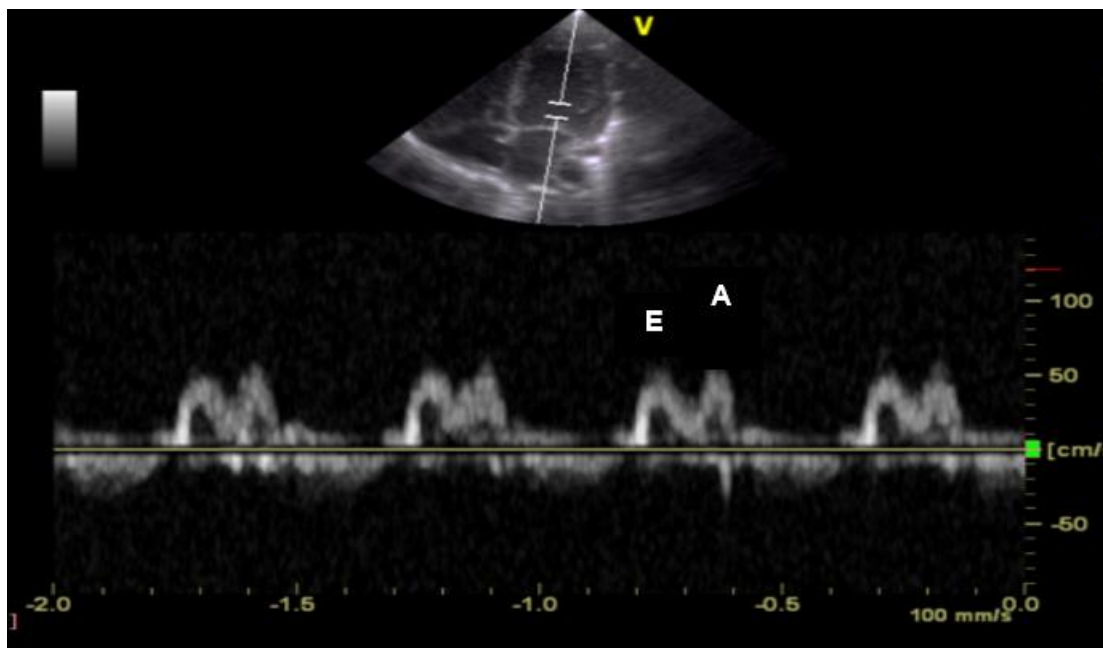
3 Pulsed-wave Doppler pattern of mitral inflow
